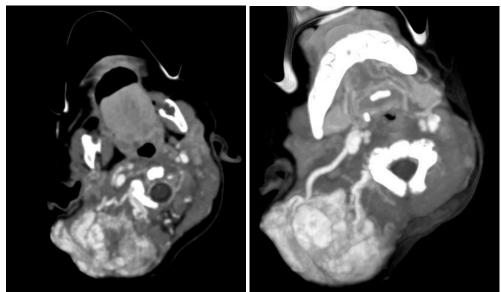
The axial view of the CT angiography reveals a nidus predominantly supplied by the enlarged vertebral artery and a branch from the right external carotid artery. The venous drainage is observed into the right internal jugular vein
